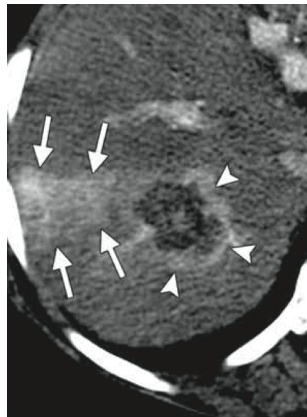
Example of hyperaemia immediately after thermal ablation where arrowheads show a relatively thick rim of transient periablation hyperaemia and arrows indicate arterioportal shunting around the RFA zone as a result of injury to smaller vessels; Reproduced from Kim *et al.*, *RadioGraphics* 31: 377-390
